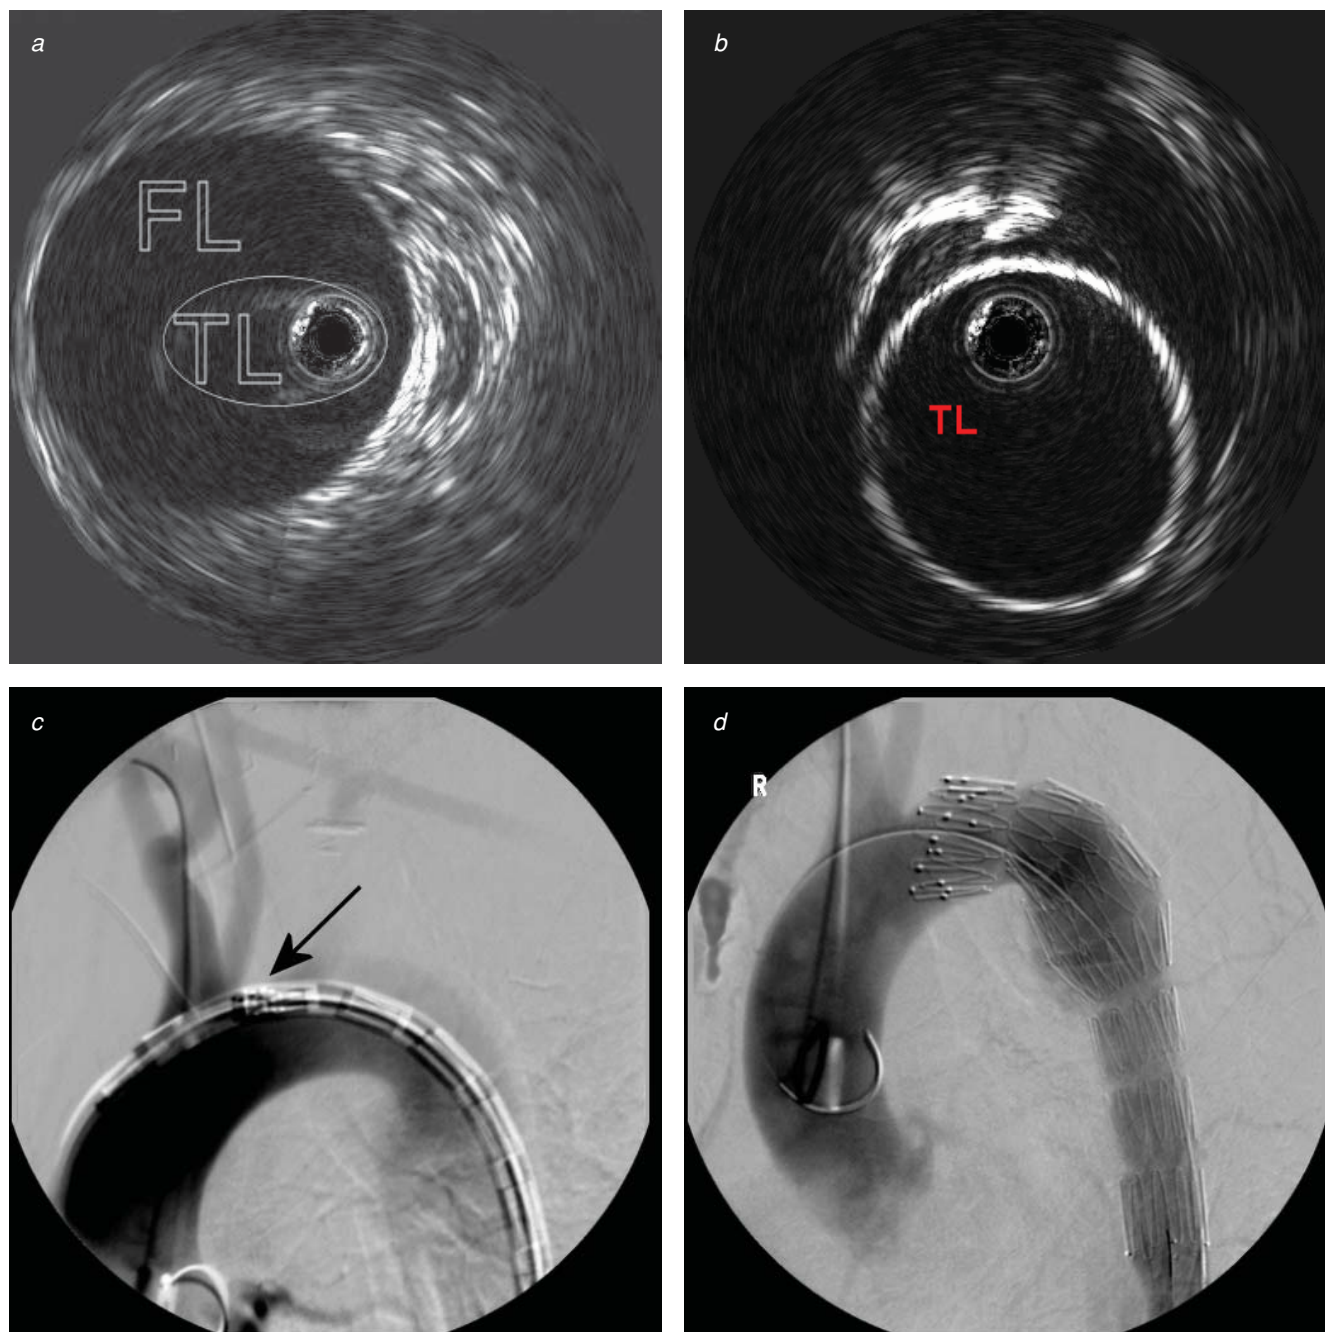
(a) Intravascular ultrasonography (IVUS) of acute type B dissection with “floating” true lumen (TL) that is enhanced by the circle. Endovascular repair of acute type B aortic dissection. (b) IVUS of expanded TL after endovascular repair of acute type B dissection. (c) Thoracic aortography showing the stent graft in the descending thoracic aorta. The proximal portion of the graft (*black arrow*) is placed at the level of the left common carotid artery, covering the left subclavian artery to obtain proximal seal in normal aorta. (d) Thoracic aortography showing stent graft deployed with obliteration of the proximal false lumen. FL = false lumen.
